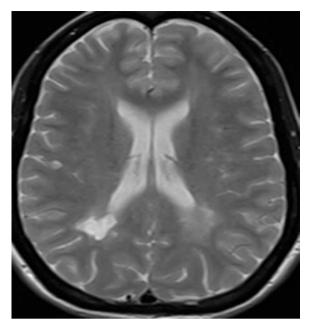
Axial MRI (T2).
